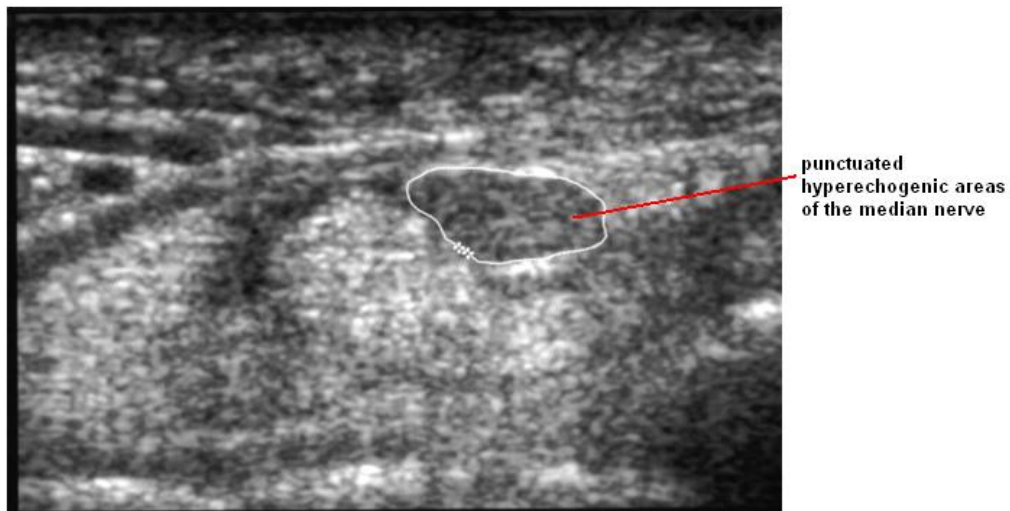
Transverse sonogram of the median nerve
